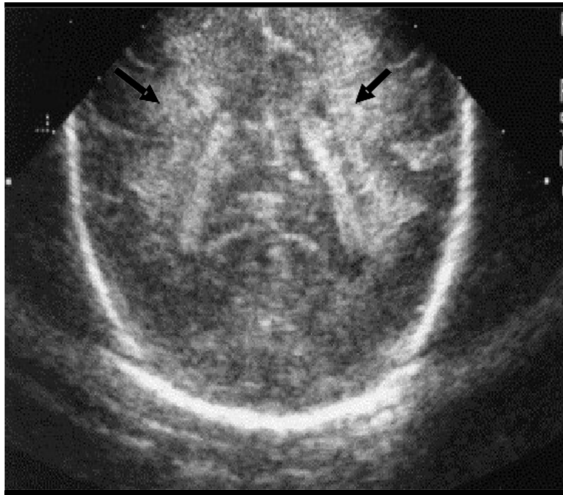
(a) Coronal ultrasound view from preterm infant at 5 days of age. Note the increase echogenicity within periventricular white matter⁽⁴⁶⁾.
